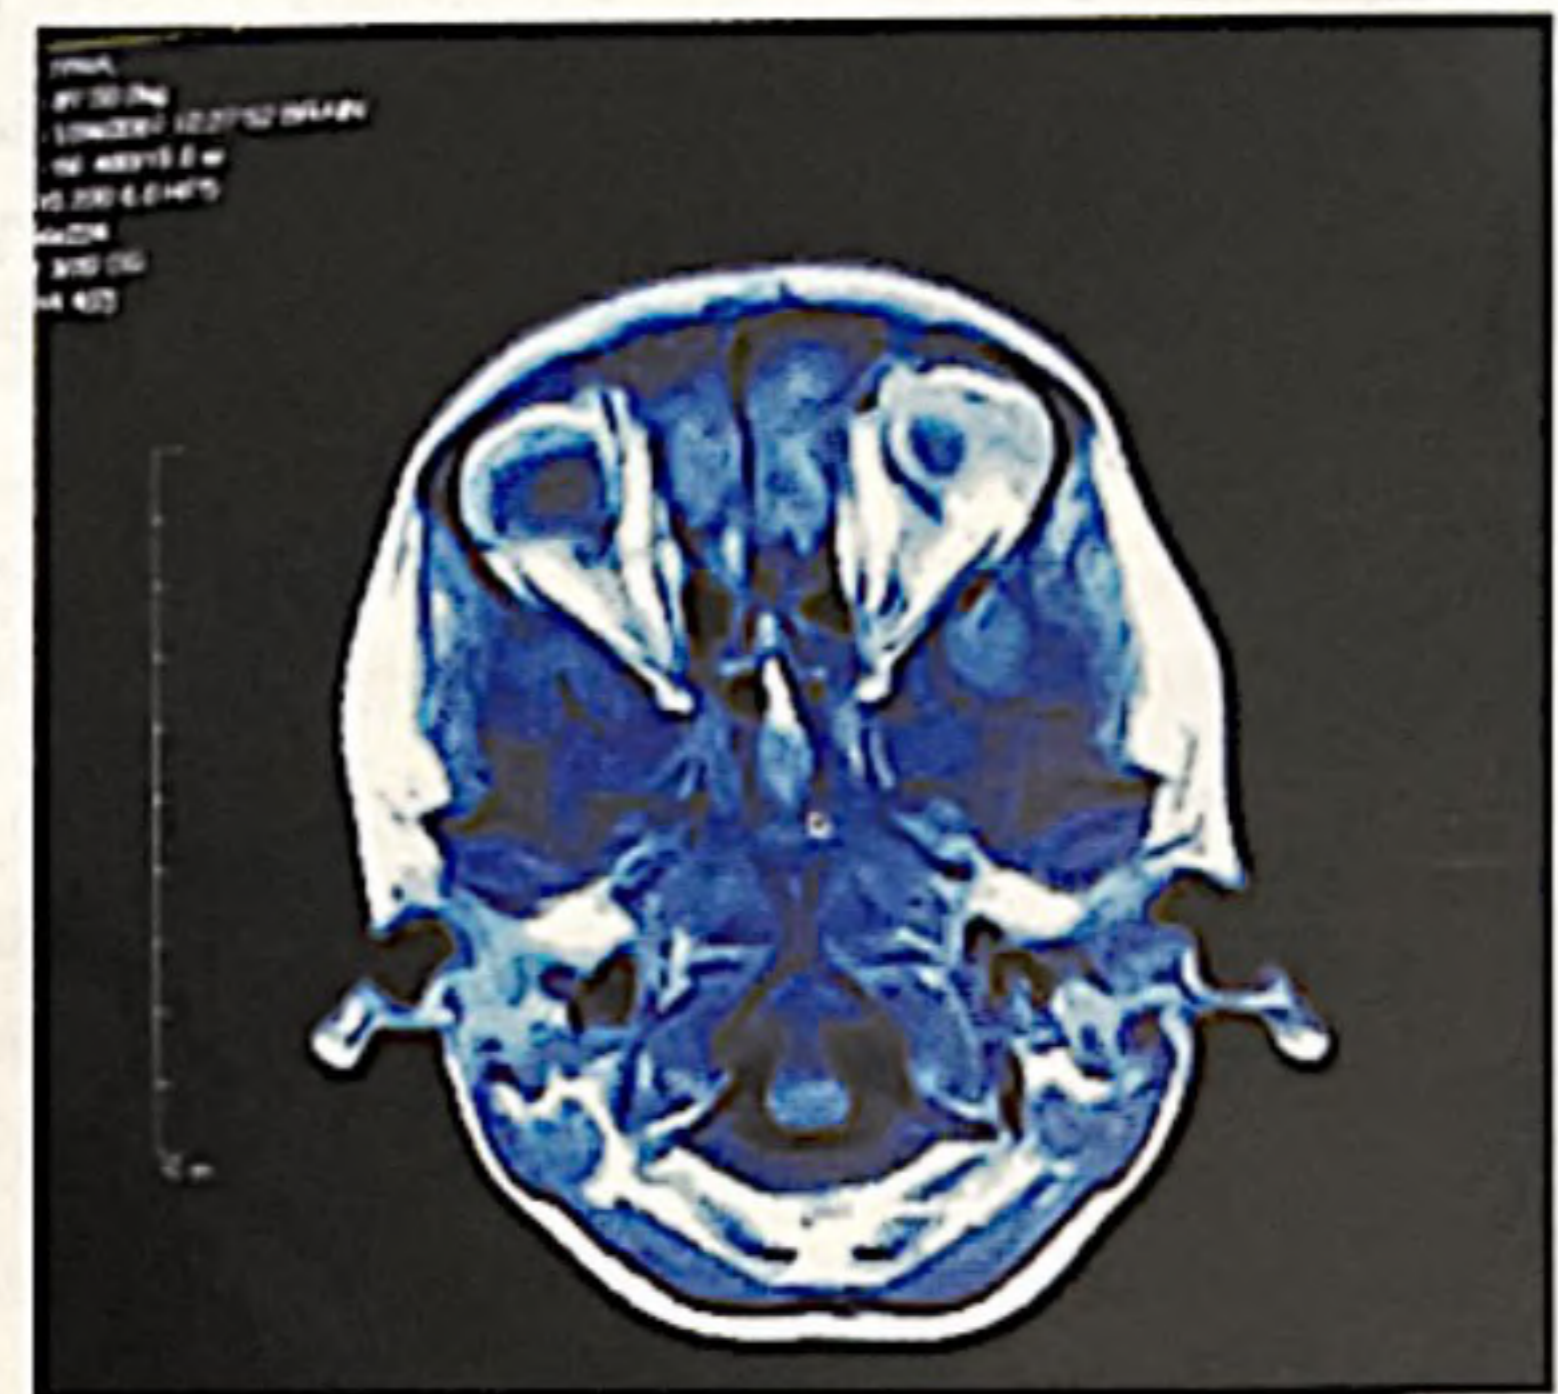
MRI of brain in axial view of T2 image showed enlarged pituitary gland (8.8x8.6 mm).
